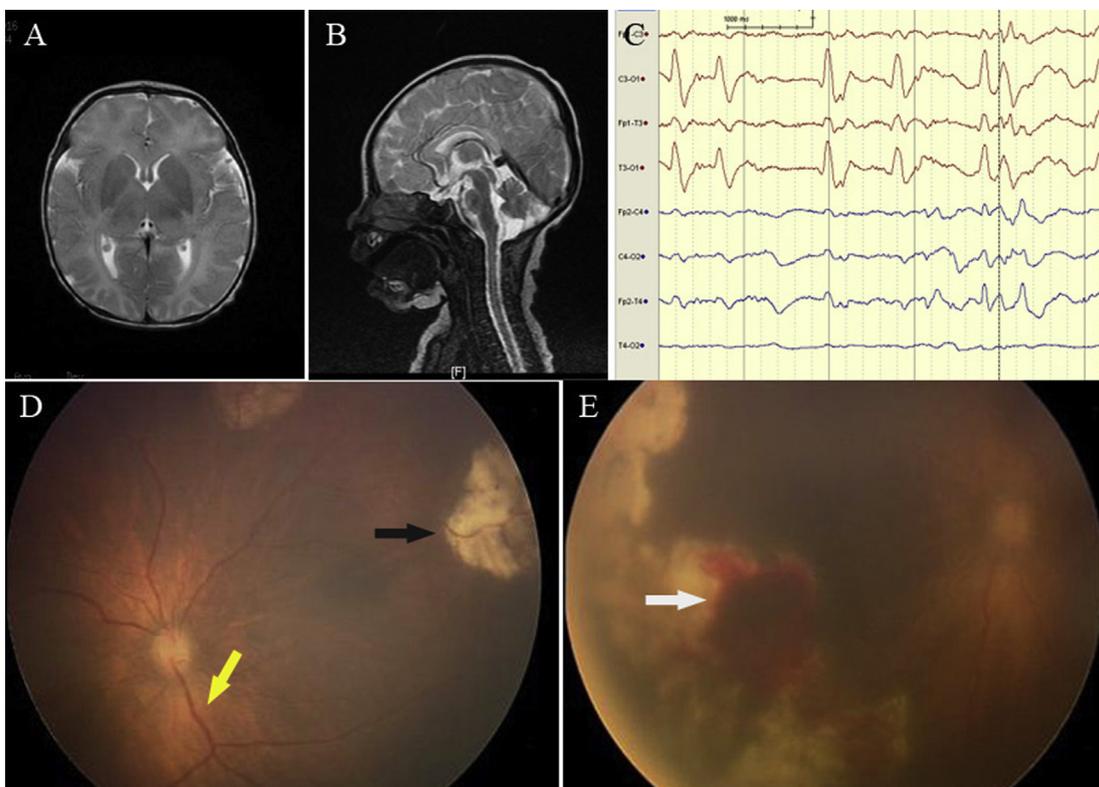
A,B. Diffused lesions with equal intensity in the regions of occipital, parietal, and temporal lobes and around bilateral ventricles were observed in T2-weighted MRI. C. EEG revealed multifocal epileptiform abnormalities. D,E. Fundus photography at initial presentation showed confluent white areas of necrosis at the periphery (black arrow), with hemorrhages (white arrow) and possible vasculitis (vascular dilatation and tortuosity; yellow arrow) (D: right eye, E: left eye).
